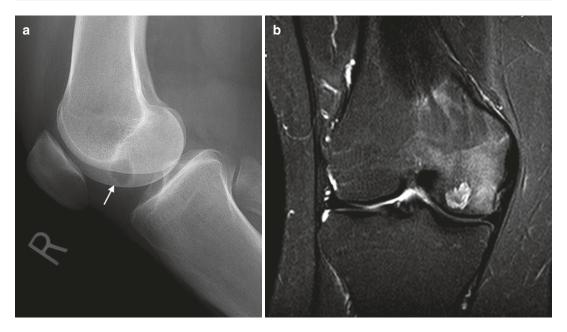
Chondroblastoma in an 18-year-old male presenting with knee pain. (a) Lateral radiograph knee demonstrates a well-defined lytic lesion with thin sclerotic rim in the epiphysis medial femoral condyle (*arrow*). (b)
